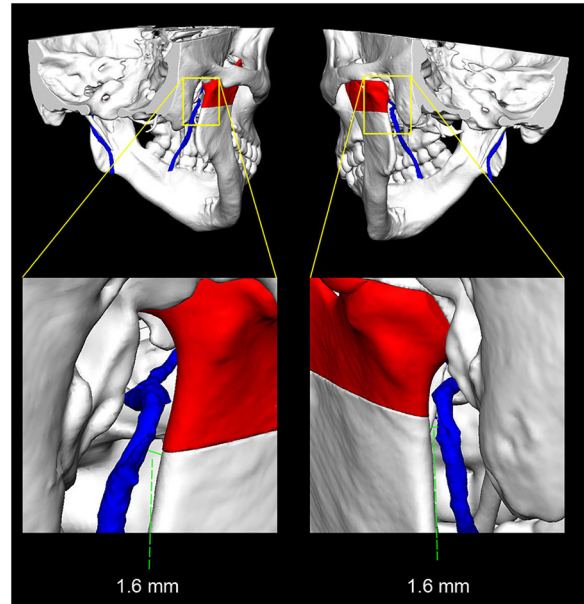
Computed tomogram showing ankylosis of the temporomandibular joint and position of maxillary arteries (blue).
